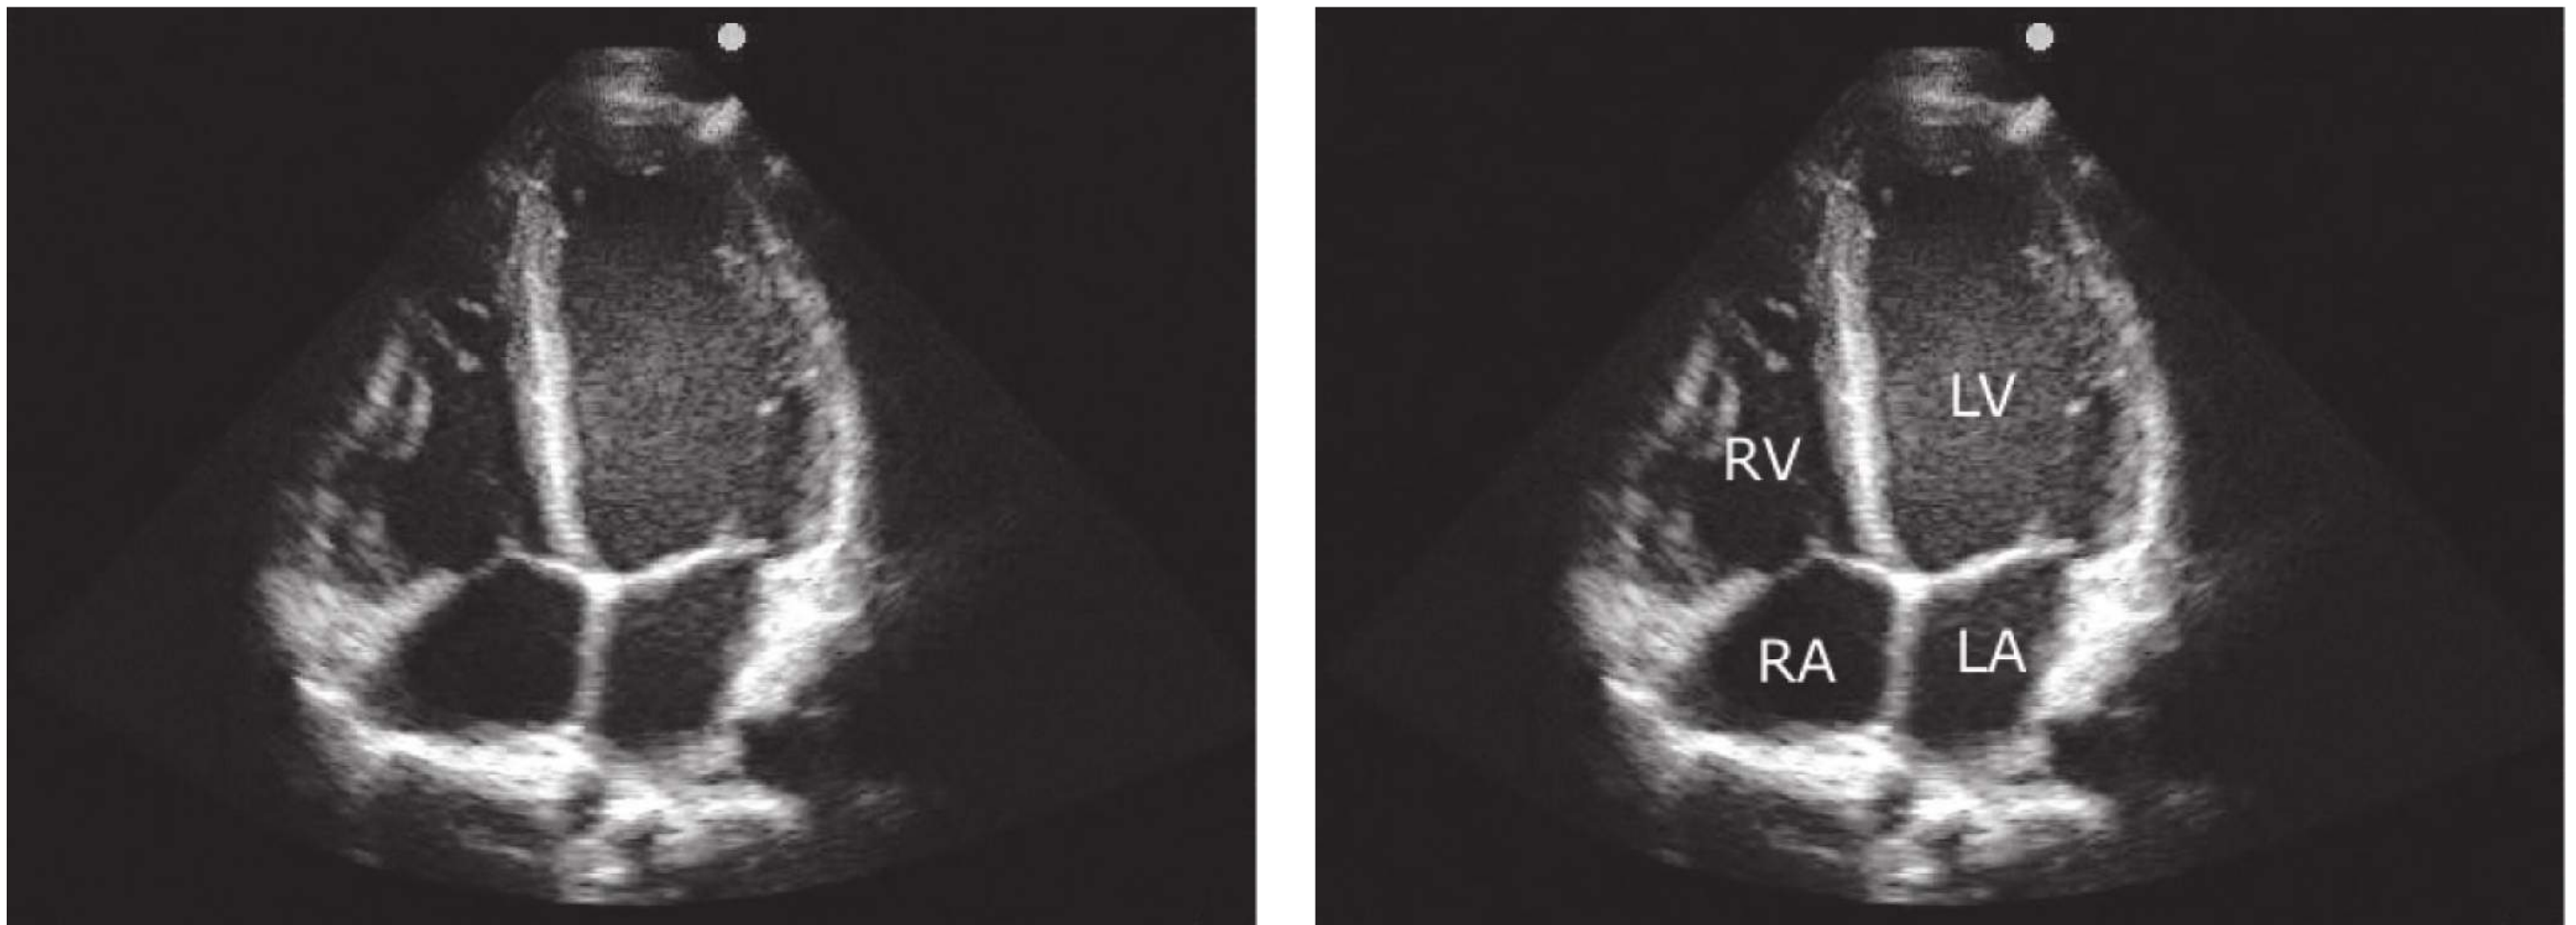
Apical four-chamber view of a normal heart. Note the normal right to left ventricular size ratio of $< 0.6:1$.
